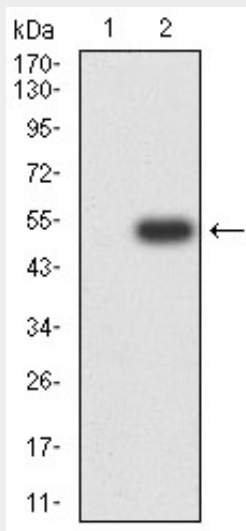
Western blot analysis using PSMA mAb against HEK293 (1) and PSMA (AA: extra 44-177)-hlgGfc transfected HEK293 (2) cell lysate.
